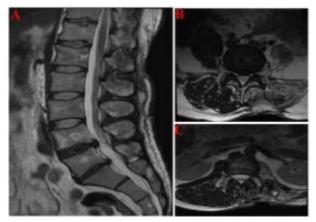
A; Uncontrasted T2-weighted sagittal lumbar vertebra MRI section taken after the third surgery, changes related to the previous surgery are observed in the posterior part of the L2-L4 vertebral corpuscles. No recurrence or residual mass was detected. B and C; postoperative uncontrasted T2-weighted MRI sections of the axial lumbar vertebra. Except for postoperative changes, no recurrence or residual tumour tissue is observed.
